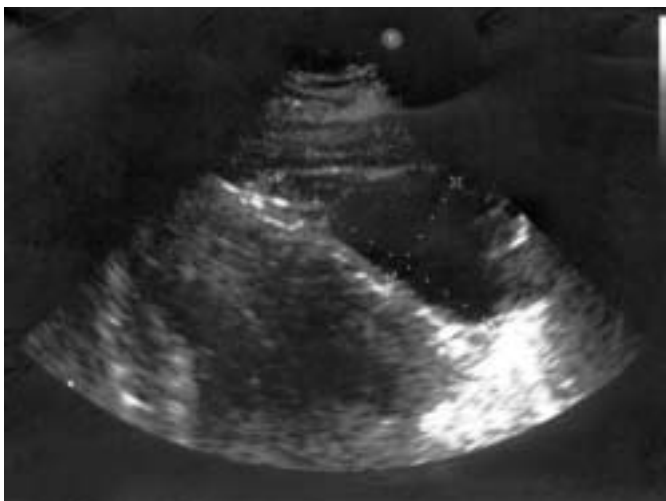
Transthoracic ultrasound.
